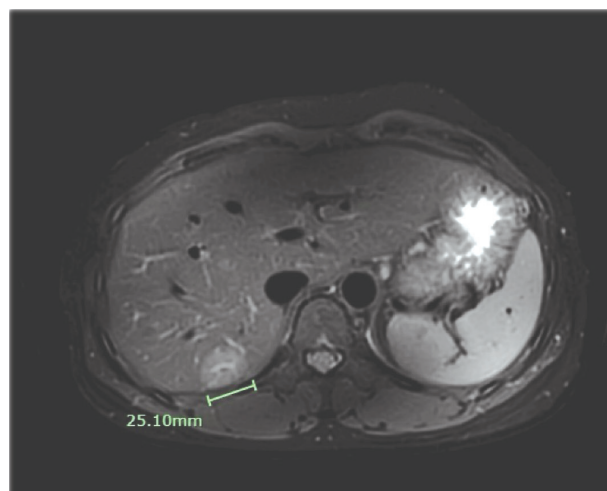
MRI scan shows the mass size of 2.5 cm at segment VII.
